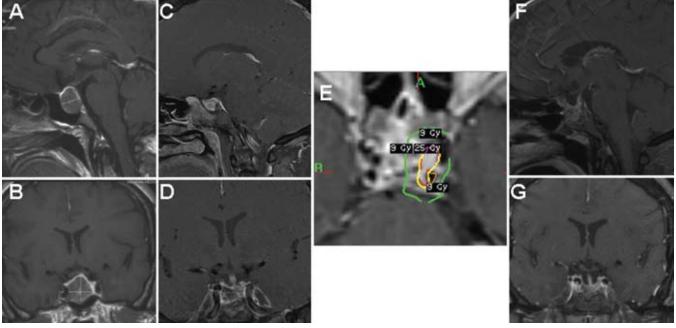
Case example. A 55-year-old woman presented with acromegaly (GH level 36 ng/ml [reference level < 11 ng/ml] and IGF-I = 1200 μ g/L [reference range 81–225 μ g/L]) and a 15 × 22 × 18-mm adenoma with left cavernous sinus invasion, seen on T1-weighted Gd-enhanced sagittal (A) and coronal (B) images. The patient underwent transsphenoidal surgery for the adenoma 2 weeks after the MR images were obtained. Six weeks after surgery, postoperative MR imaging revealed residual tumor in the left cavernous sinus, seen again on T1-weighted Gd-enhanced sagittal (C) and coronal (D) images. Six weeks after surgery, her postsurgical GH and IGF-I levels were 2 ng/ml and 344 μ g/L, respectively. The latter value, along with MR imaging showing residual adenoma, was indicative of persistent postoperative acromegaly. Four months after transsphenoidal surgery, the patient underwent GKS to target residual adenoma in the left cavernous sinus, prescribed to a dose of 25 Gy to the 54% isodose line (E). Twenty months after radiosurgery and 2 years after diagnosis, the IGF-I level normalized to 200 μ g/L, the GH level remained normalized to 1 ng/ml, and T1-weighted Gd-enhanced sagittal (F) and coronal (G) images showed no residual enhancing tissue, consistent with remission of acromegaly.
